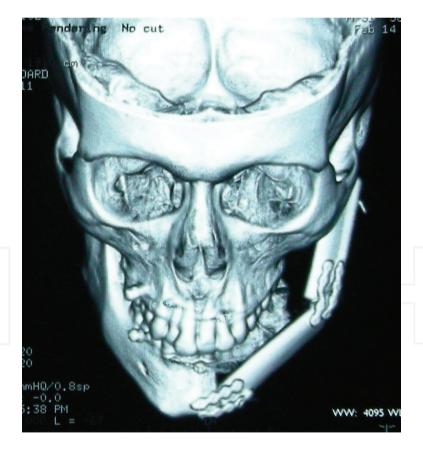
Postoperative 3D CT scan showing mandibular reconstruction with fibula free flap.
